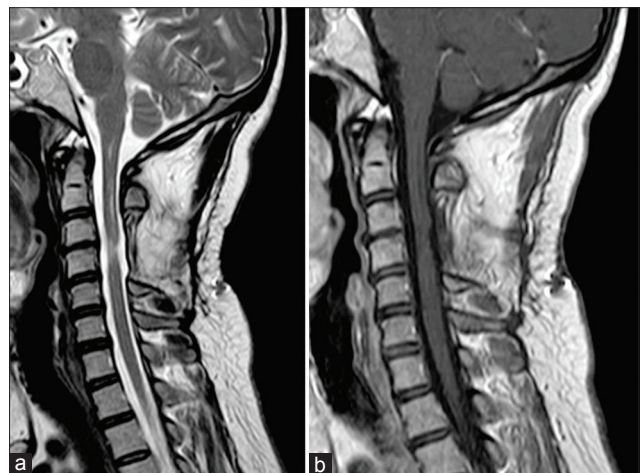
(a and b) One-year follow-up imaging. T2-weighted sagittal image (a) and postgadolinium sagittal image (b) showing thinning of the cord at the operated level and no residual lesion
